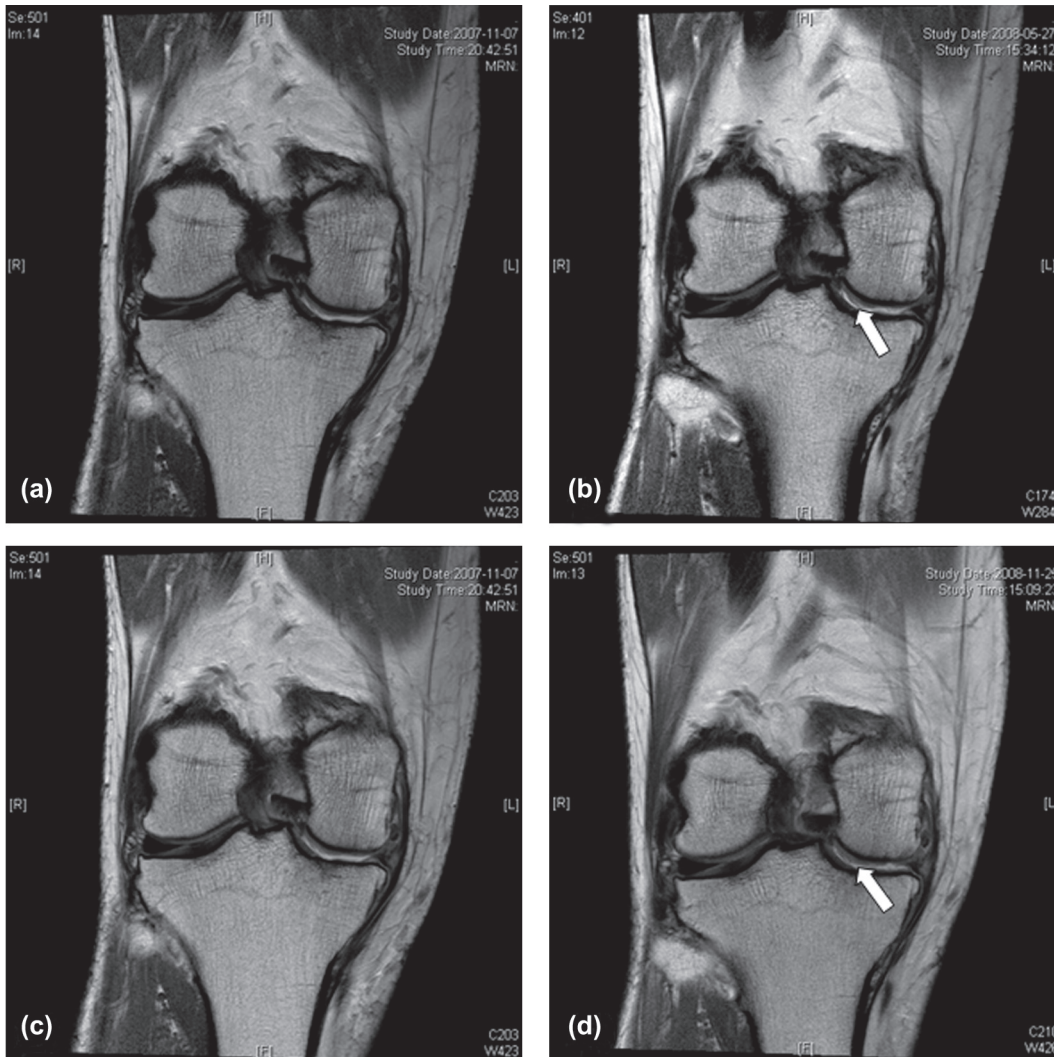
Proton-density coronal magnetic resonance image for patient 011 at baseline (a, c), 6 months (b) and 12 months (d). The appearance of cartilage regeneration is seen in (b) and (d), especially around the periphery of the grade 4 lesion site at the medial femoral condyle, as indicated with the arrow.
